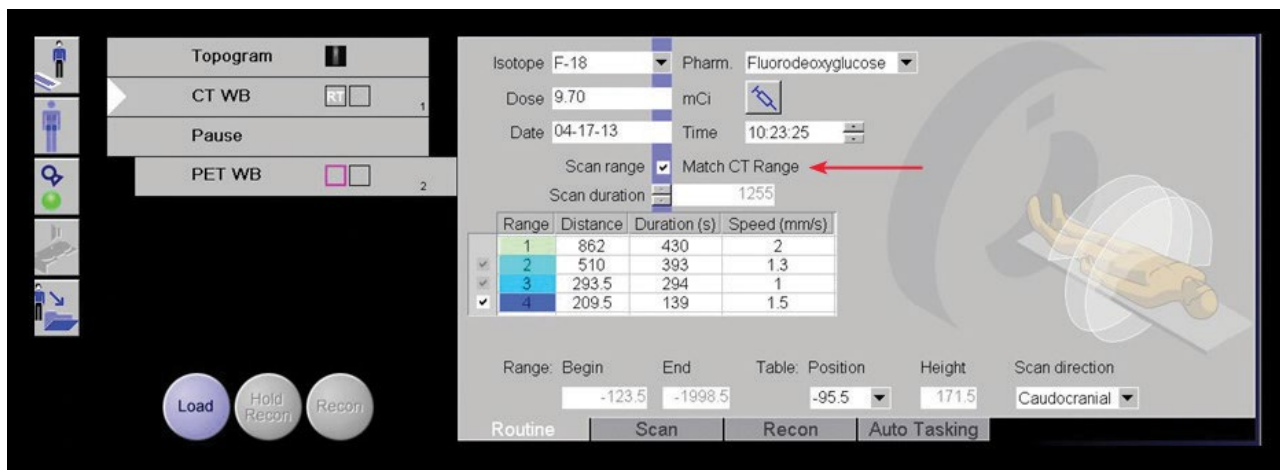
Scan Range - Match CT Range.
